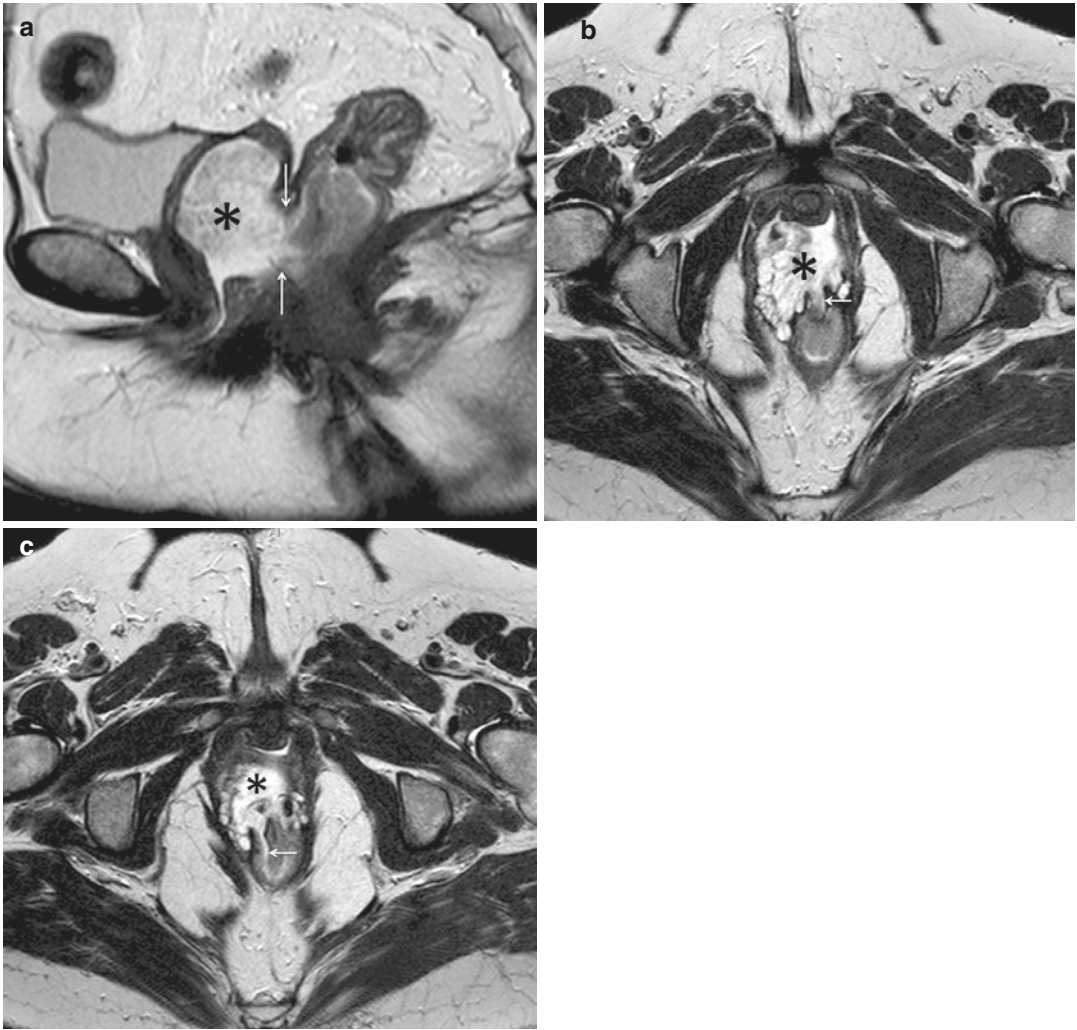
Recto-vaginal communication. Hysterectomized patient. Sagittal (a) and axial-oblique (b, c) T2-weighted TSE images clearly depict a wide defect of the posterior vaginal wall (arrows in a). On
